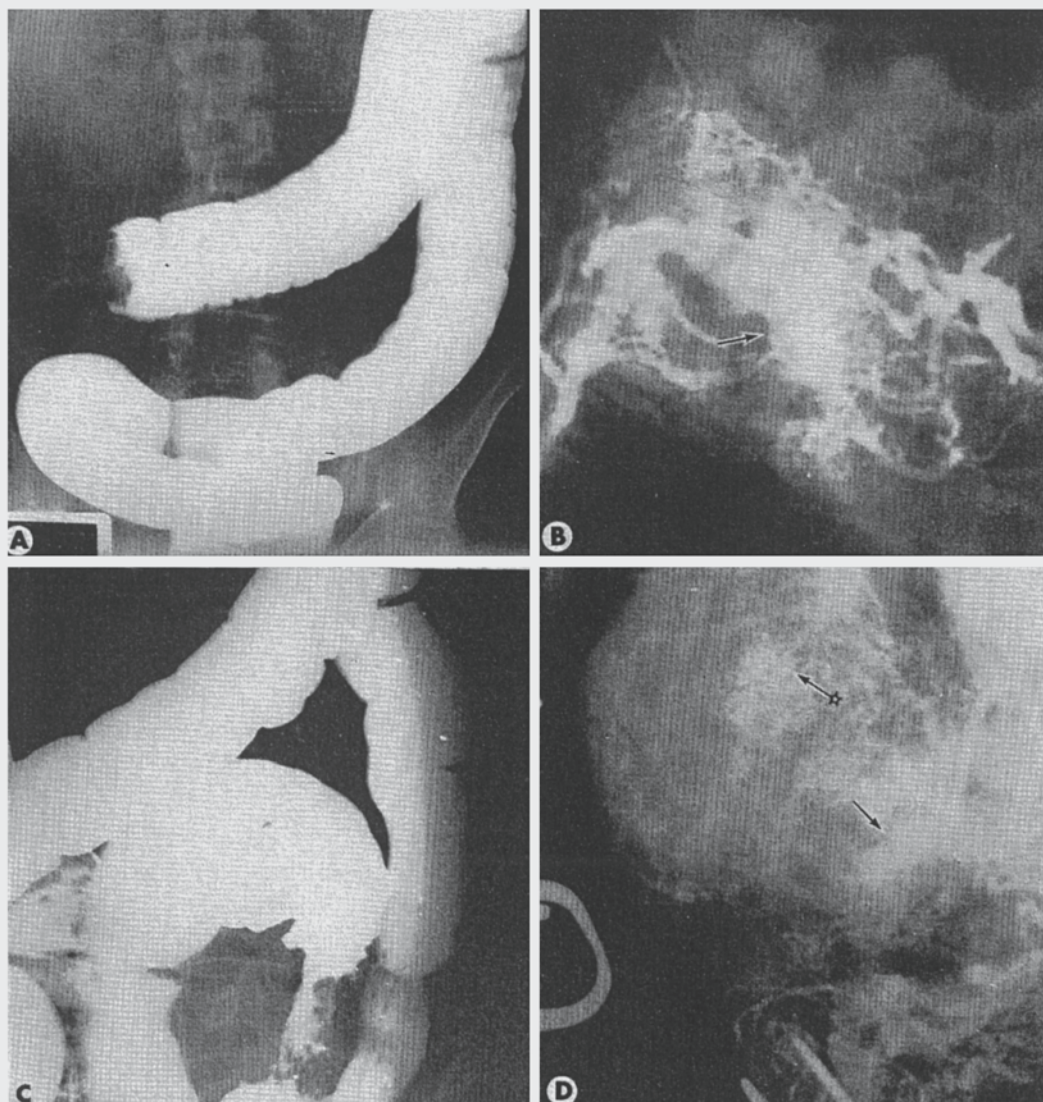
(A and B) Annular carcinoma of the transverse colon. (A) A pre-evacuation barium enema roentgenogram showing the lesion. (B) An operative mesenteric arteriogram showing the lesion. The vessels are irregular and show sharp turnings. The blood vessels, in general, are more numerous than in the surrounding areas; however, close to the top of the lesion there are fewer vessels. Areas of dense opacification are seen in the tumor (arrow). (C and D) Carcinoma of the sigmoid colon. (C) Barium enema roentgenogram. (D) A mesenteric arteriogram, *in vivo*. Irregular, chaotically arranged vessels are seen throughout the tumor. There are areas of dense opacification (arrow) as well as smaller multiple perivascular areas of leaking (arrow with star).
